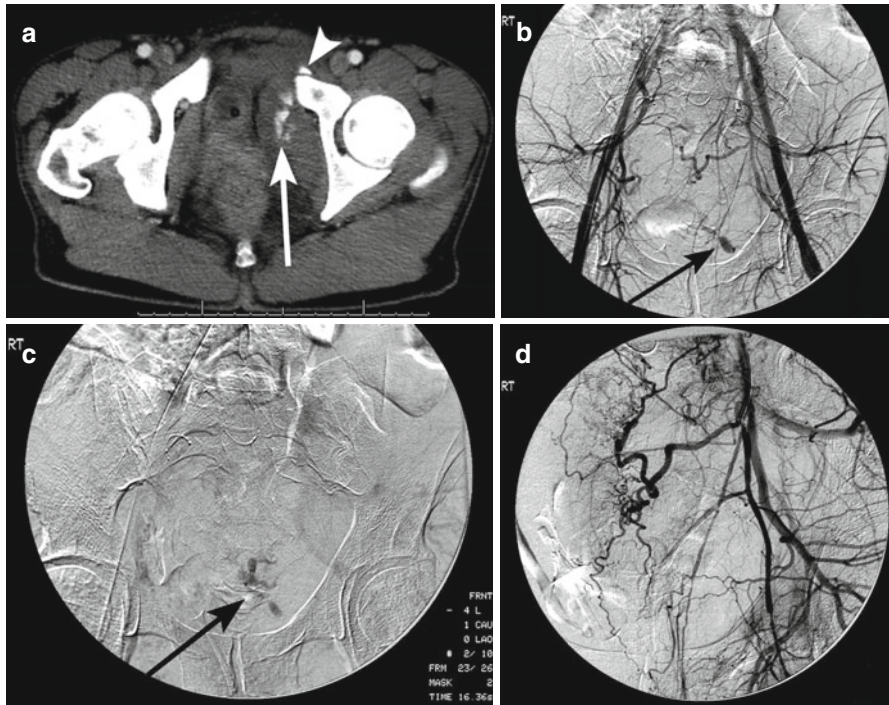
A 42 year-old female presents after motor vehicle accident. (a) Post-contrast computed tomography (CT) images of the pelvis performed during the arterial phase shows focal active hemorrhage (*arrow*) in the left obturator internus muscle and fracture of the adjacent superior pubic ramus (*arrowhead*). (b) Arterial phase image during angiography shows the site of active bleeding (*arrow*) from the left obturator artery. (c) On the delayed phase, more extravasated contrast (*arrow*) has accumulated. (d) After selection of the left obturator artery and infusion of Gelfoam slurry, a repeat angiogram shows that the bleeding has stopped
